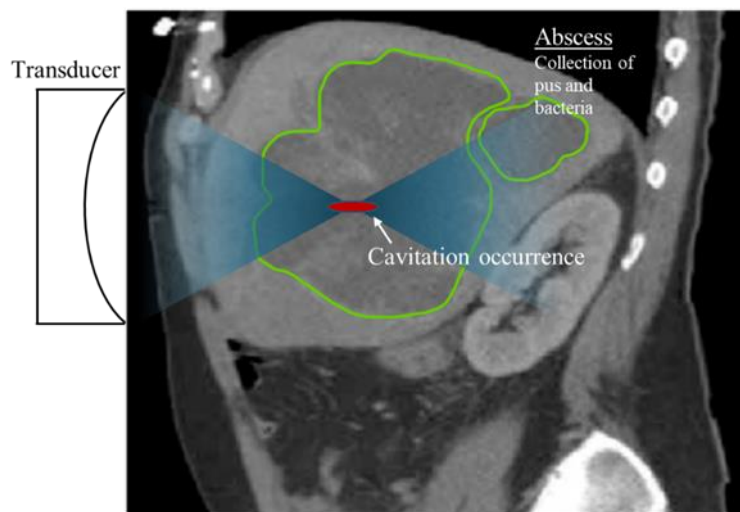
Hypothesized process of histotripsy-based abscess treatment. A CT scan of a deep abscess is shown. A transducer focuses the ultrasound beam in the abscess interior leading to formation of cavitation, which will liquefy the abscess contents and inactivate bacteria. Treating the whole abscess interior is possible by moving the focus under image-guidance and recirculation of contents close to the boundary into the focus by cavitation-induced streaming.
